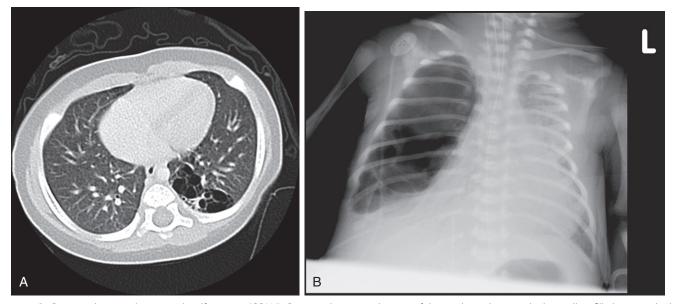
A, Congenital cystic adenomatoid malformation (CCAM). Computed tomography scan of the newborn shows multiple, small air-filled cysts in the left lower lobe. This infant had this diagnosis made by antenatal ultrasound. B, Anteroposterior chest radiograph of newborn shows a large air-filled cyst filling most of the right hemithorax. Smaller cysts on the right are apparent, although not as well delineated. The right lower lobe is compressed, and the mediastinum is shifted to the left. This infant had this diagnosis made by antenatal ultrasound. (A, Courtesy Sameh Tadros, MD, Pittsburgh, Pa; B, courtesy Beverly Newman, MD, Pittsburgh, Pa.)
